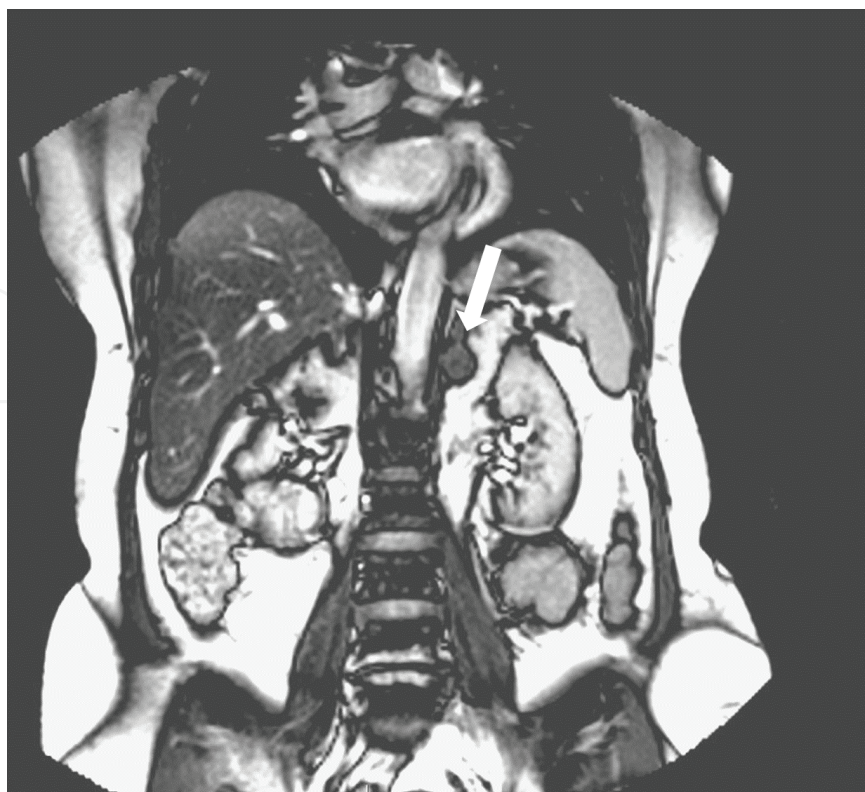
MRI: left adrenal cortical adenoma.
